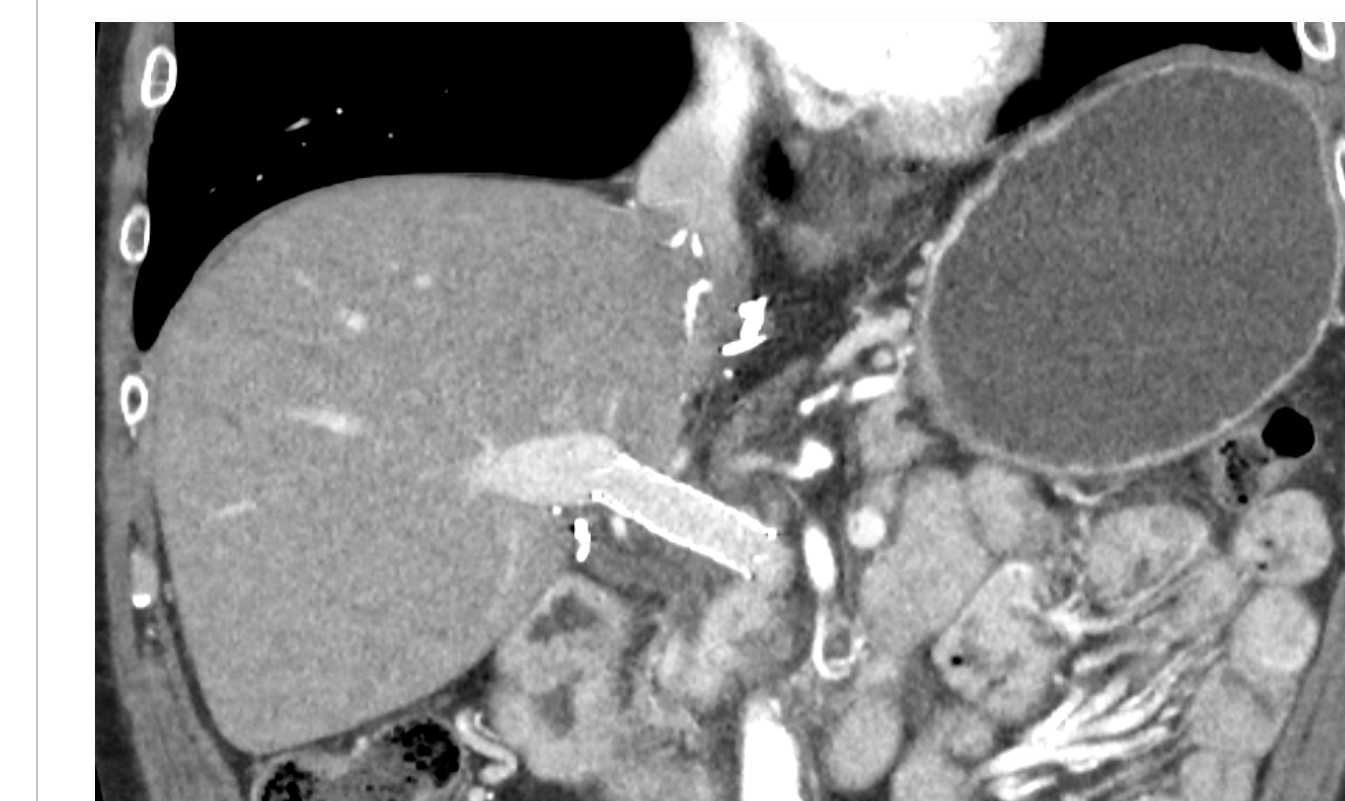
b): Follow up CT of the same patient demonstrates patent portal vein and stent status post stenting with 12 mm diameter x 40 mm length Epic self expanding stent.
